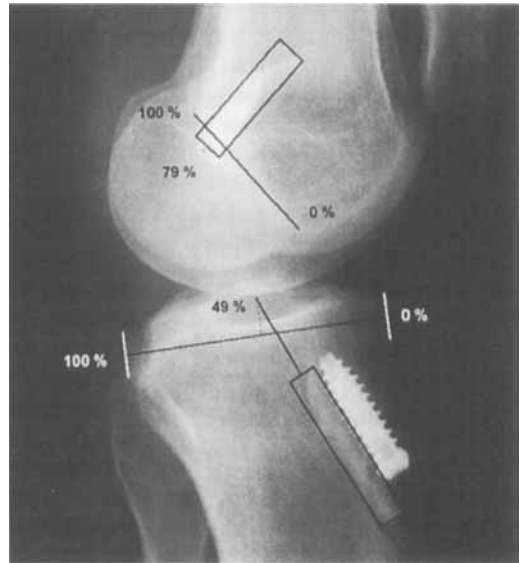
Postoperative radiographic image with bone blocks and interference screws. Measurement techniques shown.
